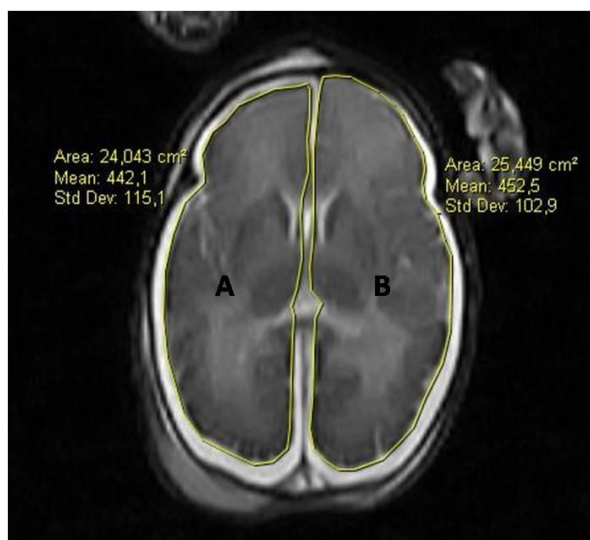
39 weeks of gestation age. transverse cranial MR image of a male fetus. A. Right hemispherium cerebri areas calculated by outlining the boundaries of the right hemispherium. B. Left hemispherium cerebri area calculated by outlining the boundaries of the left hemispherium.
